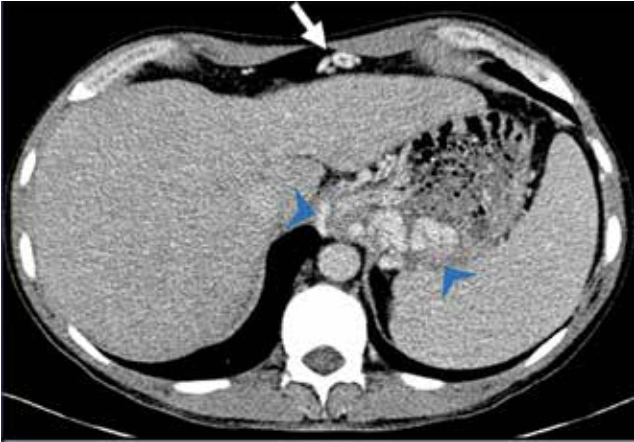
Axial contrast-enhanced CT image demonstrated sequela of portal hypertension with recanalized umbilical vein (white arrow) and a large gastroesophageal variceal complex (blue arrowheads).
